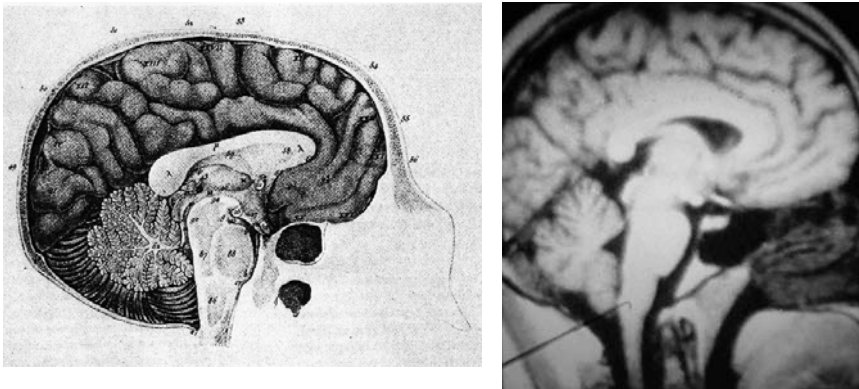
Early 19th-century anatomic depiction of the brain by Franz Joseph Gall (left) and 1980s MRI scan of the brain (right).⁴
